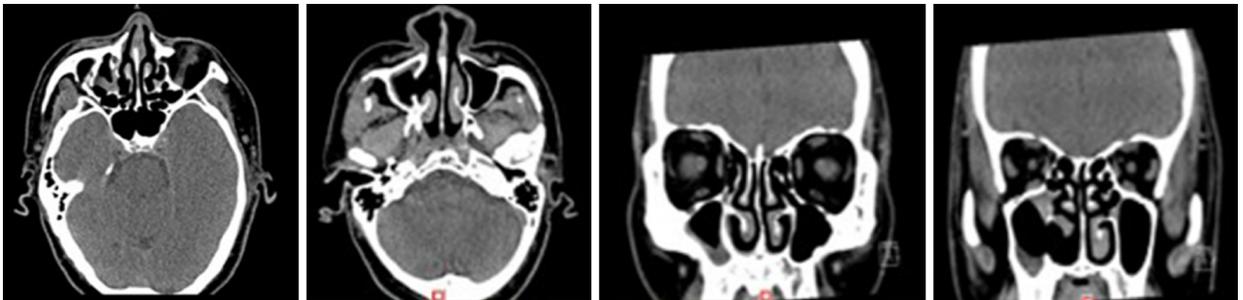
Postoperative re-examination (June 6, 2019). Axial and sagittal paranasal sinus computed tomography scans showed that the right lateral wall of the maxillary sinus was locally absent, and the mucosa in the sinus cavity was thickened. Other sinus cavities contained good air content and no abnormally dense shadow.
